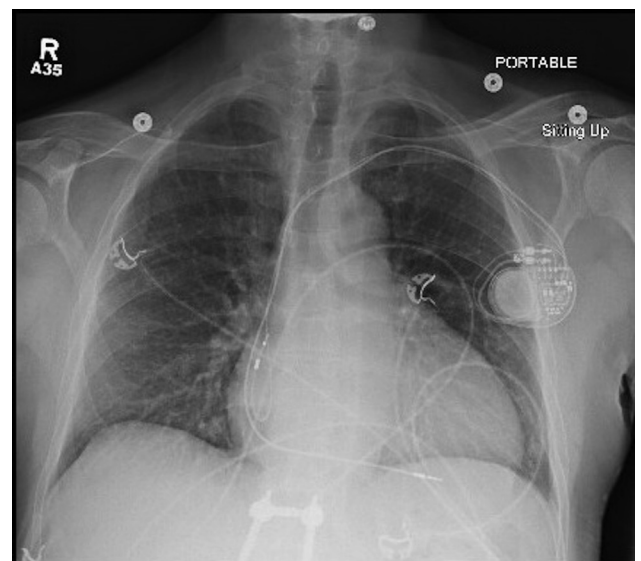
Chest x-ray demonstrating mild cardiomegaly with a dual-chamber pacemaker but otherwise radiographically clear lung fields.
